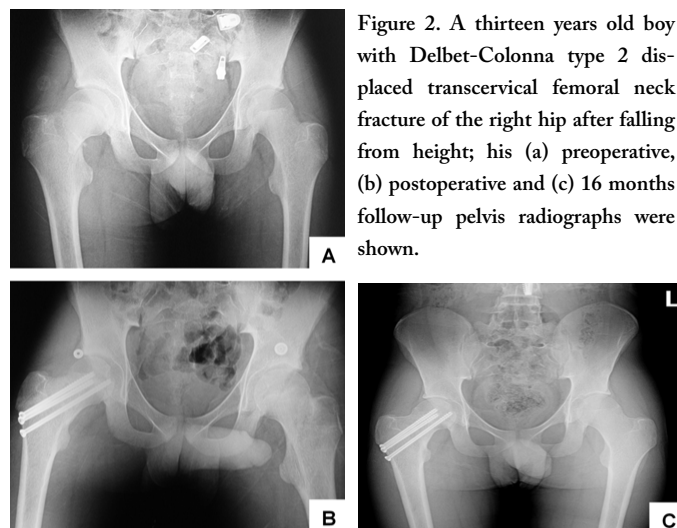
A thirteen years old boy with Delbet-Colonna type 2 displaced transcervical femoral neck fracture of the right hip after falling from height; his (a) preoperative, (b) postoperative and (c) 16 months follow-up pelvis radiographs were shown.
